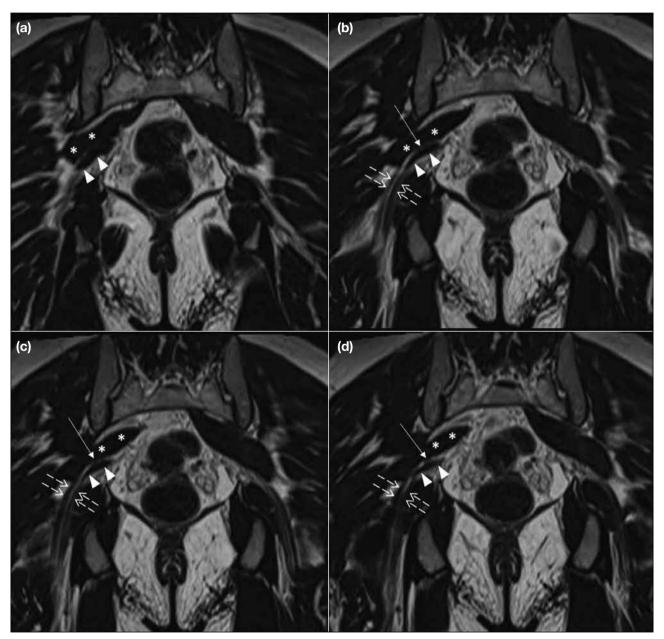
(a-d) T1-weighted coronal magnetic resonance images of the pelvis (repetition time: 400 ms, echo time: 10 ms): from posterior to anterior. Aberrant muscle fibres of the piriformis muscle (arrowheads) are noted anterior to the main bulk of the piriformis muscle (asterisks). The common peroneal division of the sciatic nerve (solid arrows) passes between the main bulk and aberrant muscle fibres of the piriformis muscle.
